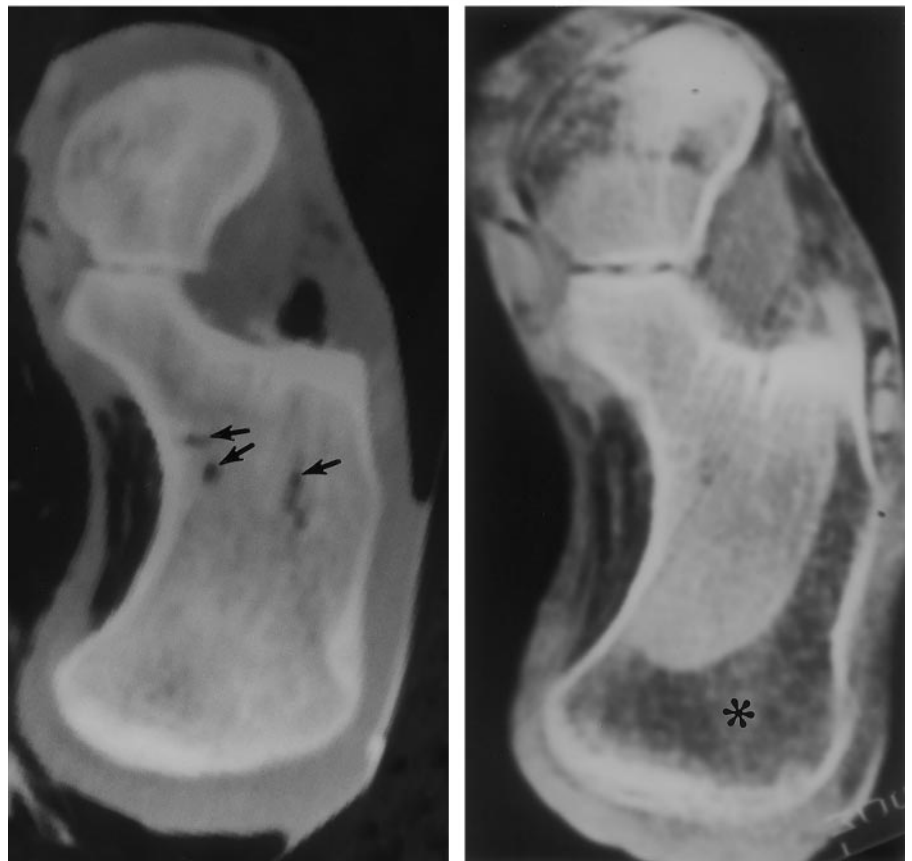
Marrow air distribution changes with time. (a) Transverse CT section through the left calcaneus (obtained on September 26, 1991) shows generally homogeneous water attenuation in cancellous marrow. Several small collections of air (arrows) are present in the marrow. Air is also present in soft-tissue planes and spaces. (b) Transverse CT section through the left calcaneus (obtained on May 3, 1994) more than 2½ years later shows a different marrow appearance, with much more air (*) in the calcaneal marrow space. Note a similar change in the talus and the soft tissues. It is postulated that the bones of the feet partially thawed in the interval. Air replaced marrow water that drained from portions of the marrow space.
